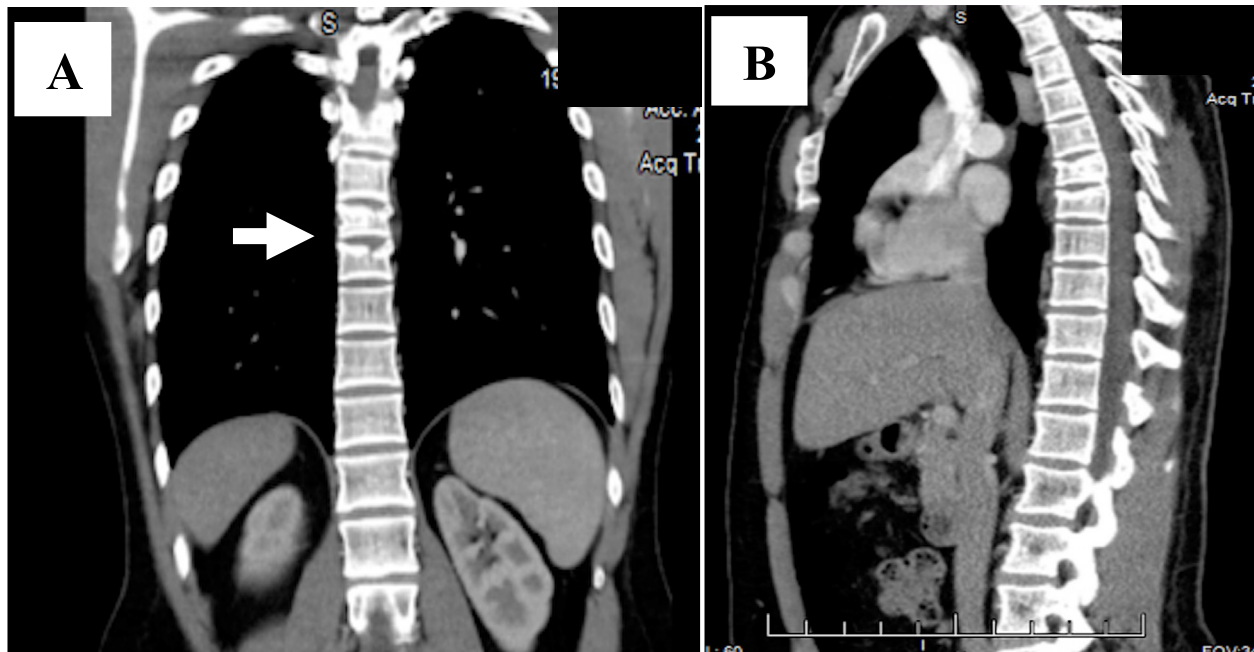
(A) Computed tomography of the chest (coronal view) showing fracture deformities of the thoracic 6th – 8th vertebral bodies (white arrow); (B) Sagittal view.
